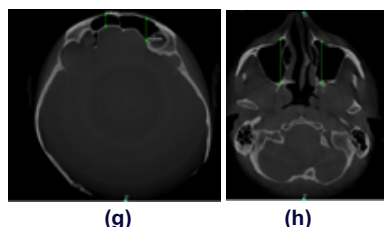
Figure (g) and (f): CBCT images showing measurement of anteroposterior dimensions of frontal ((g) and maxillary (h) sinus from axial section.
